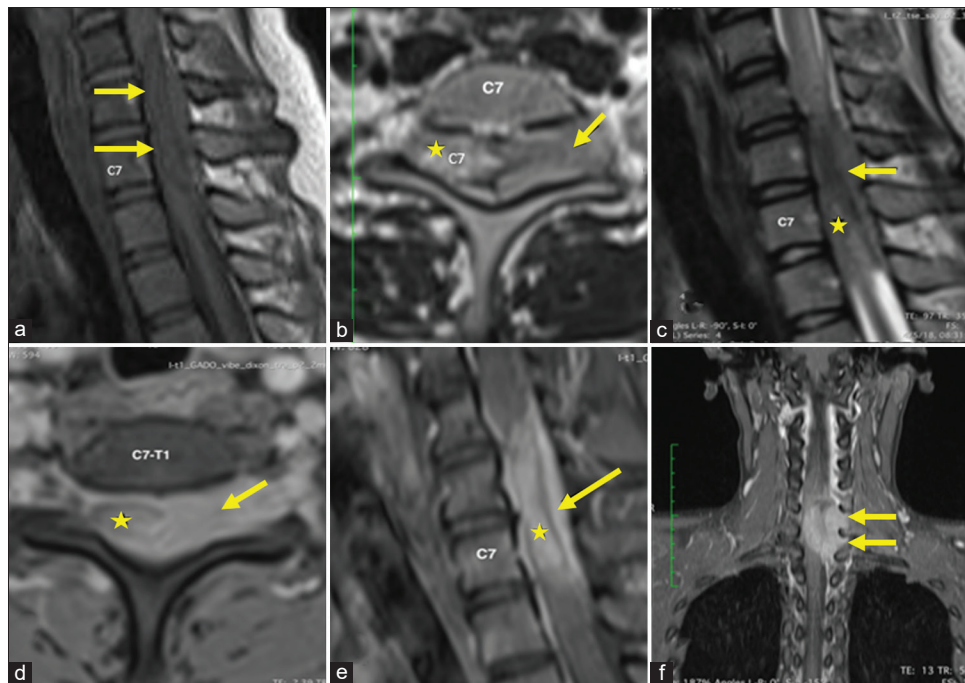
Magnetic resonance imaging of the cervical spine without gadolinium reveals a lesion which is hypointense (arrows) on the T1W sagittal (a) image. The lesion appears lightly hyperintense on the T2W axial (b) and sagittal (c) image with an intradural (star) and extradural (arrow) portion. Both components are enhanced after gadolinium injection on the T1W axial (d) and sagittal (e) image, which expands through the foramen on the T1W coronal image (f) with a dumbbell-shaped pattern.
